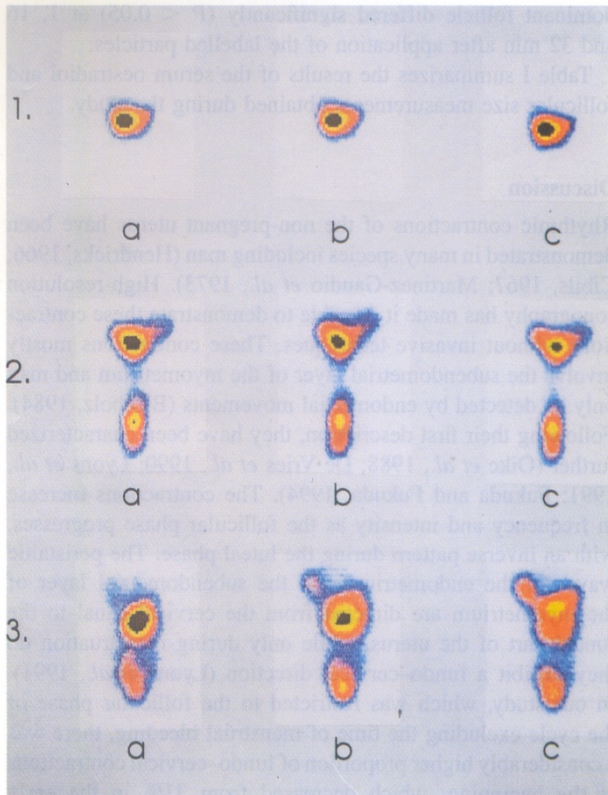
Representative colour prints obtained by hysterosalpingoscintigraphy in three different patients (panel 1, early follicular phase; panel 2, mid-follicular phase; and panel 3, late follicular phase). In each patient, scintigrams were performed at 1–2 min intervals. In this figure, only the scintigrams obtained 1 (a), 16 (b) and 32 min (c) after vaginal application of the labelled macrospheres are shown. In the patient at the mid-follicular phase (panel 2), the dominant follicle was in the left ovary, while in the patient at the late follicular phase (panel 3), the dominant follicle was situated in the right ovary.
